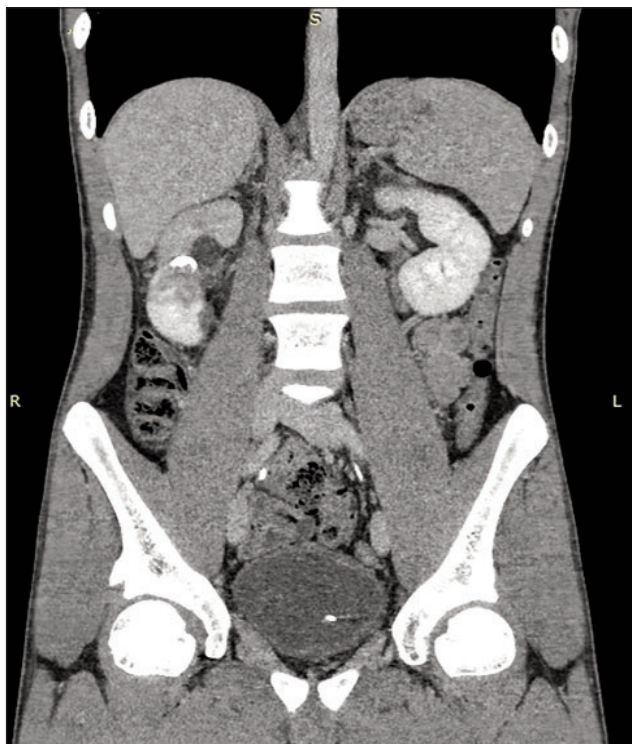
Follow-up CT urography performed four months after the initial scan. Coronal urographic-phase image demonstrates a right-sided JJ ureteric stent with the proximal pigtail positioned within the right renal pelvis. Hypoenhancement of the upper pole renal parenchyma is noted, associated with dilatation of the upper calyceal system. The previously identified retroperitoneal fluid collections have completely resolved.
